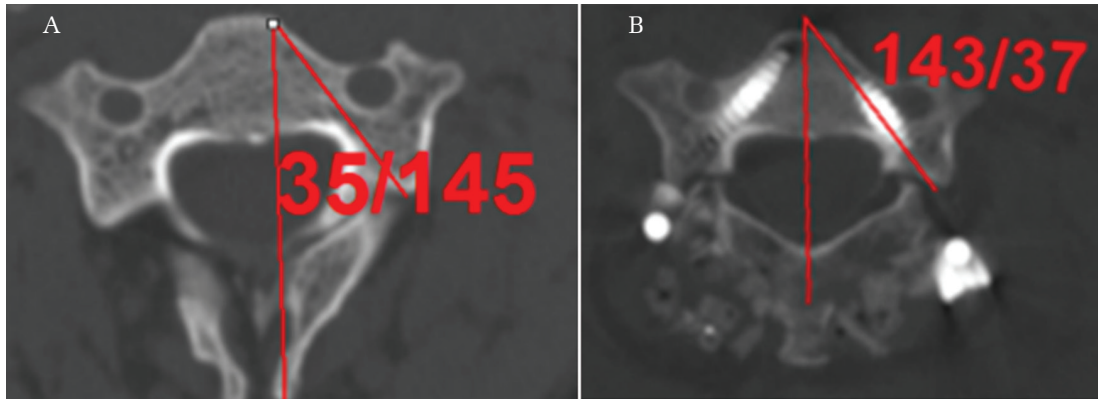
(A) Preoperative CT scan of 32-year-old male patient shows θ_{med} is 35 degrees on the left C3 level. (B) Postoperative CT scan shows grade I lateral wall violation despite θ_{ins} is 37 degrees and bigger than θ_{med} . Compared to right side screw, the left side screw seems to be thicker (i.e., 4.0 mm diameter screw). We believe that we could avoid this small amount of lateral violation, if we would use thinner screws (i.e., 3.5 mm diameter screw).
